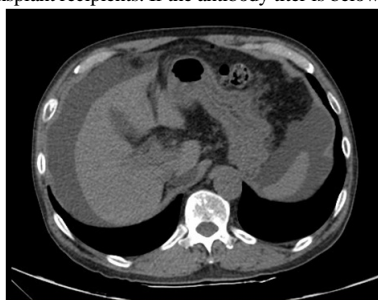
2017.10.24. Abdomen and Pelvis CT(Nonenhanced)
